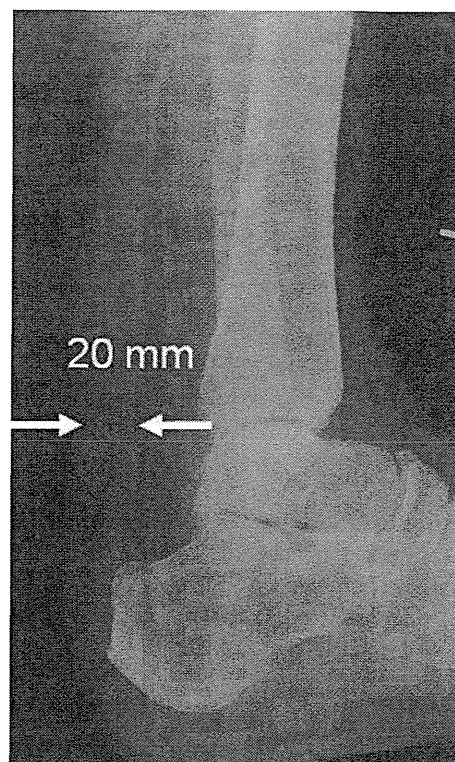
Radiography of the Achilles tendon. The measurement site of the Achilles tendon is indicated by arrows.
